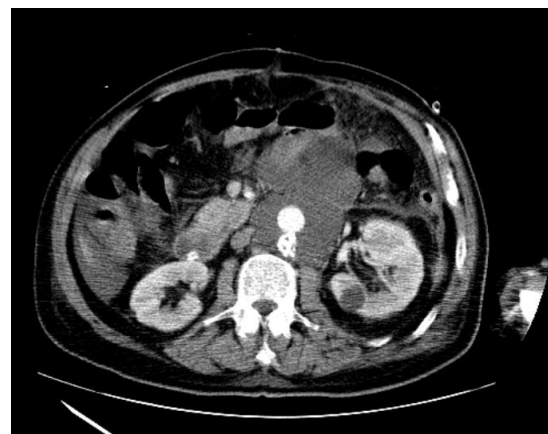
Contrast enhanced CT image showing a significant peri-aortic fluid collection
